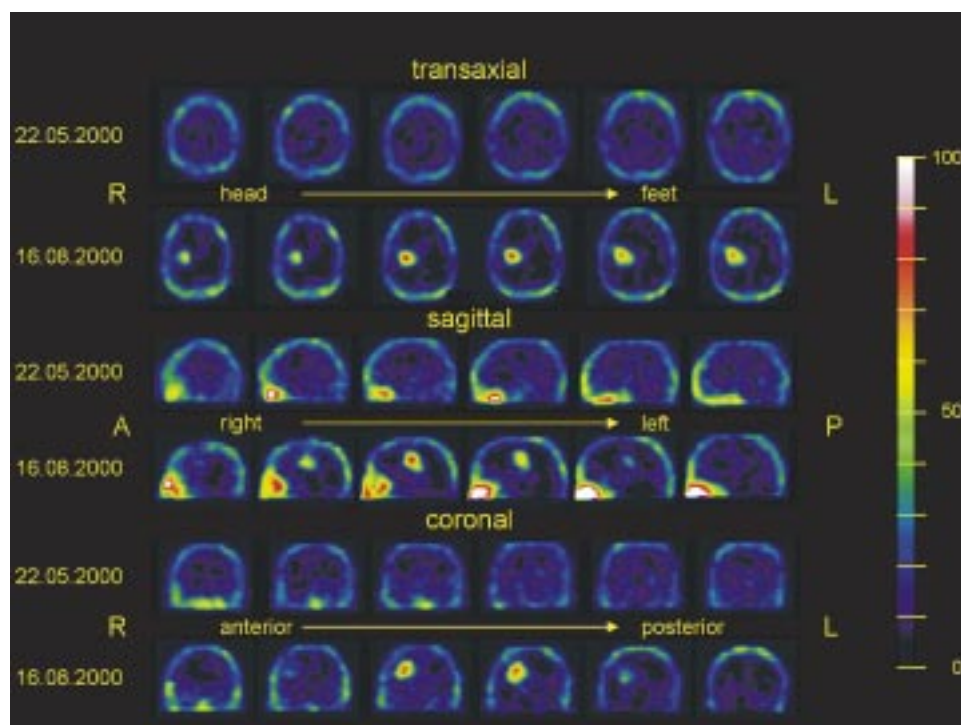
10-year-old patient with the diagnosis of an anaplastic astrocytoma III^o in the right thalamus. The patient was treated initially with chemo- and radiotherapy until 6 months earlier. The first SPECT acquired 2 hours after the application of 100 MBq ²⁰¹Tl in May 2000 showed a physiological tracer distribution. In contrast, the same study performed three months later revealed a relapse in the right hemisphere.
